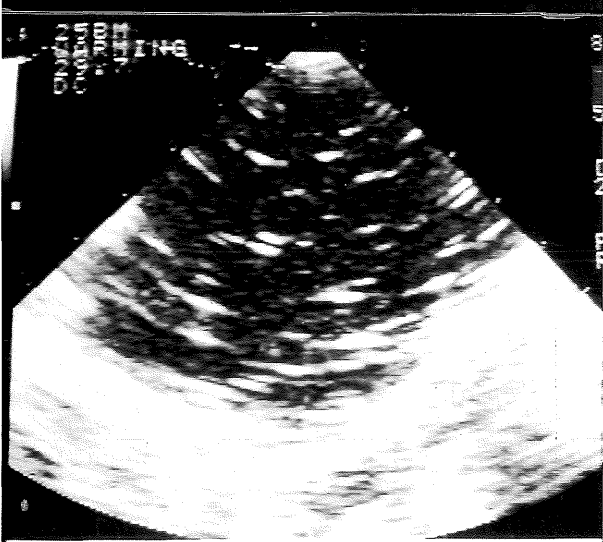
Two-dimensional transesophageal echocardiogram showing dilated left atrium and polypoid thrombus in it. LA: left atrium, T: thrombus, LV: left ventricle.
